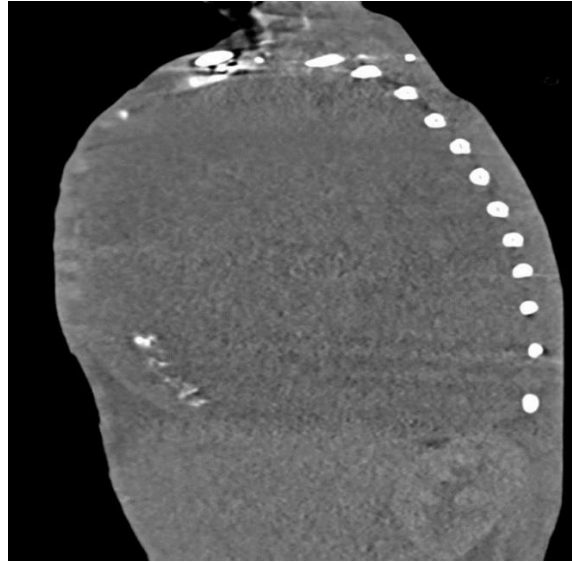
Right para-sagittal section of pre-contrast CT scan of the chest on soft tissue window showing similar lesion completely filling the right pleural cavity with non-visualized normal lung tissue and the lesion has no gross extension to the chest wall as well as to neck and diaphragmatic outlines.
